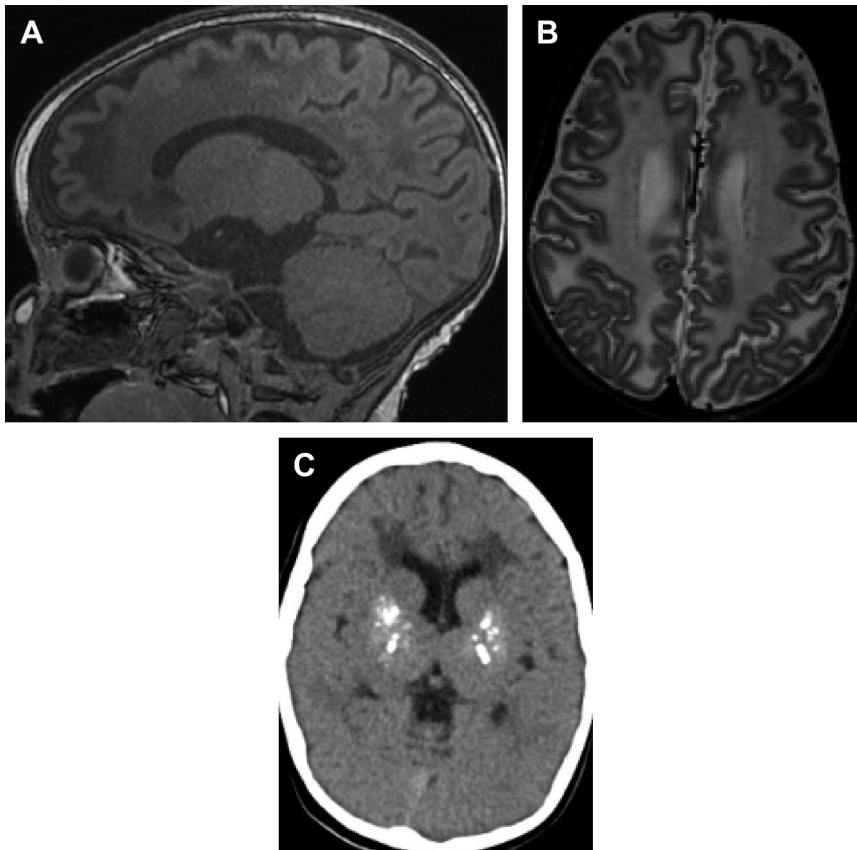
Presumed case of Aicardi-Goutières syndrome in a patient with microcephaly, hypotonia, developmental delay, and increased CSF neopterin levels. Sagittal T1 (A) and axial T2 (B) MR imaging images at 5 months demonstrate white matter signal abnormality concentrated in the subcortical region, particularly in the frontal lobes. Computed tomography images from the same patient at 2 years of age (C) demonstrate basal ganglia calcifications.
